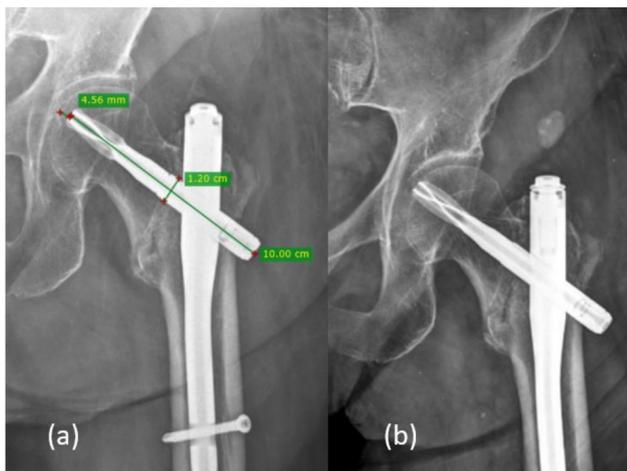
(a) Early postoperative anterior-posterior radiograph of the patient who underwent PFNA. (b) TAD change and cut-out on the 6th-week follow-up radiograph
